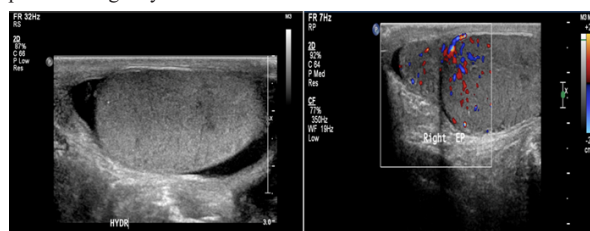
right testicular ultrasound
